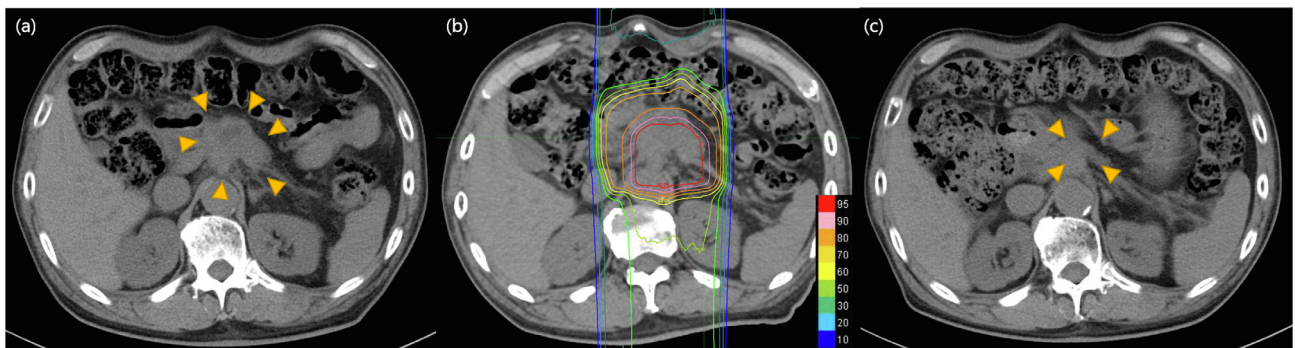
Case presentation. 71-year old man with pancreatic cancer. (a) CT before treatment. Arrows indicate gross tumor volume. (b) Dose distribution image. Total irradiation dose is 67.5 GyE and isodose lines represent 95–10% of the isocenter dose from inside to outside. (c) CT 25 months after CCRT using proton beams. Arrows indicate a reduced tumor.
